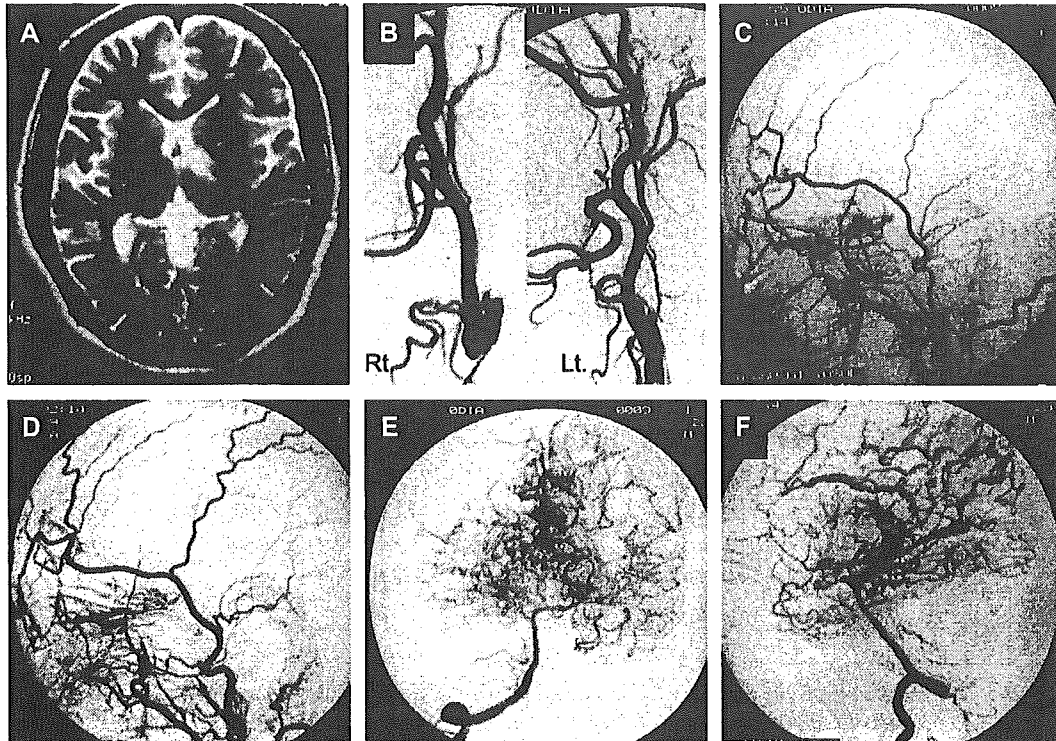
A: Axial T2-weighted image of MRI demonstrating an ischemic lesion on the knee of the internal capsule. B: Bilateral carotid angiograms disclosed occlusion of ICAs at their origins. Right (C) and left (D) external angiogram (lateral view) demonstrating transdural anastomosis. Right vertebral angiogram (anteroposterior view, E; lateral view, F) showing extensive collateral circulation via leptomeningeal anastomosis around bilateral P2 portions.
